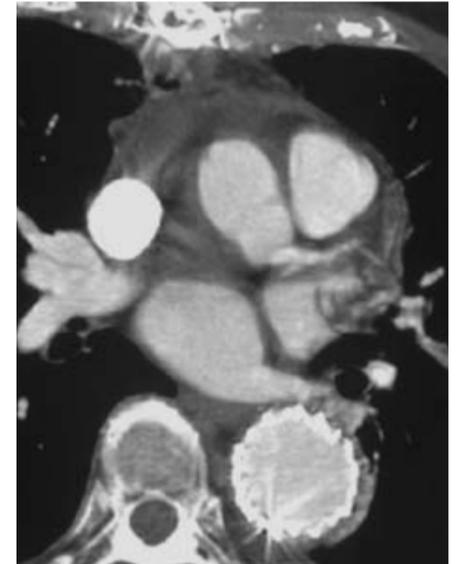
Corresponding post-operative CT section; open surgical replacement of the ascending aorta and stent graft in the descending aorta.
